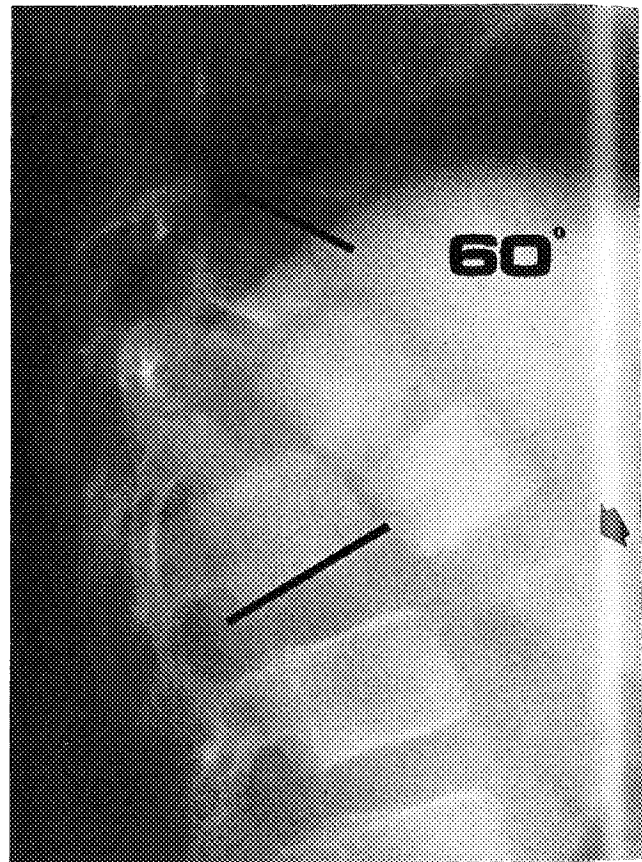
Lateral radiograph of the thoracolumbar spine. The vertebral bodies of T11 and T12 can be identified in front of L1. The radiopaque line inferior to T12 vertebral body (arrow) marks the superior end-plate of L1 vertebra. The kyphotic angle is 60°, measured from T10 to L1 levels.
